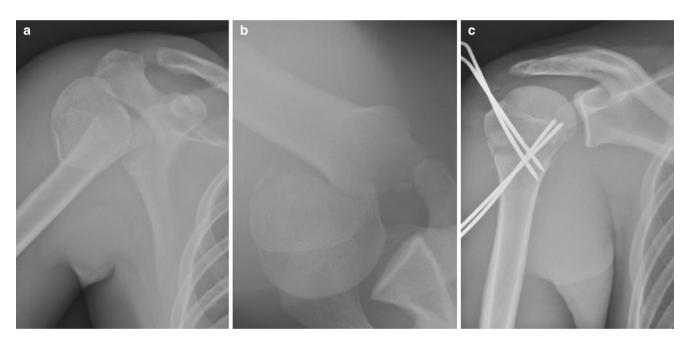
Preoperative (a), (b) and postoperative (c) radiographs after closed reduction and percutaneous pinning of an unstable, completely displaced proximal humerus fracture in a 16-year-old male
